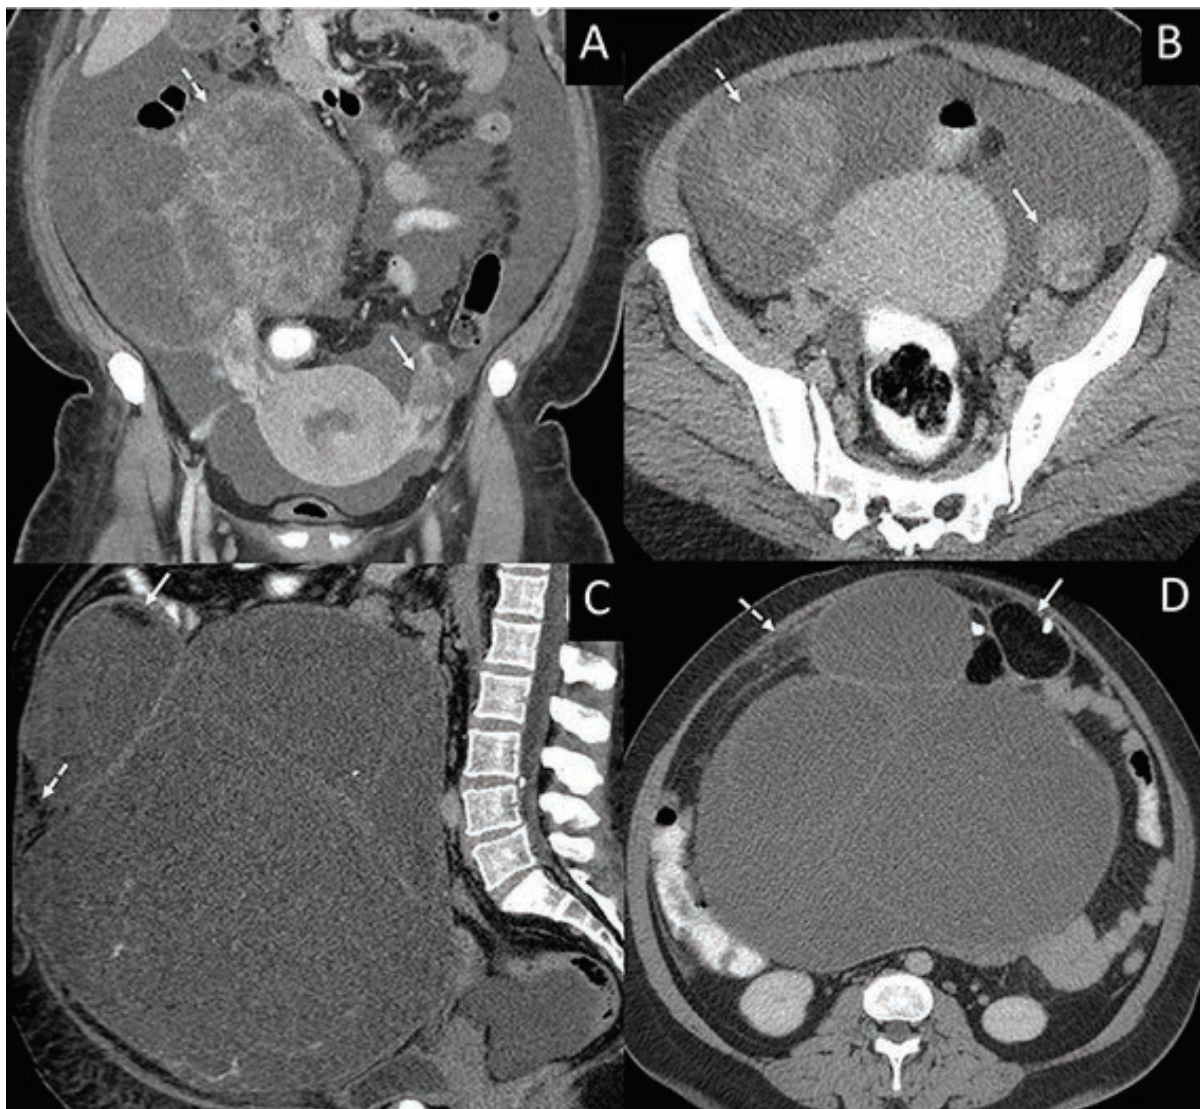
A case of a benign ovarian tumor that was wrongly classified as CT score 5, and a case of mixed cystic and fatty mass with pathologic proven for ovarian collision tumor
